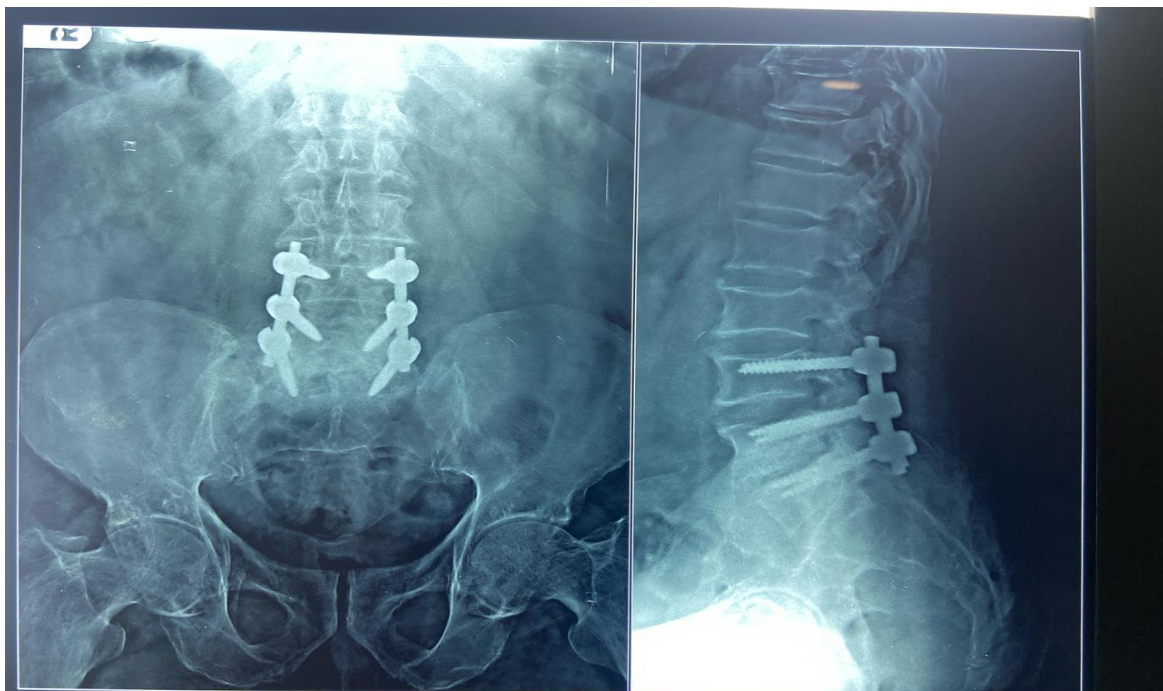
Postoperative X-ray (6 months after surgery)
